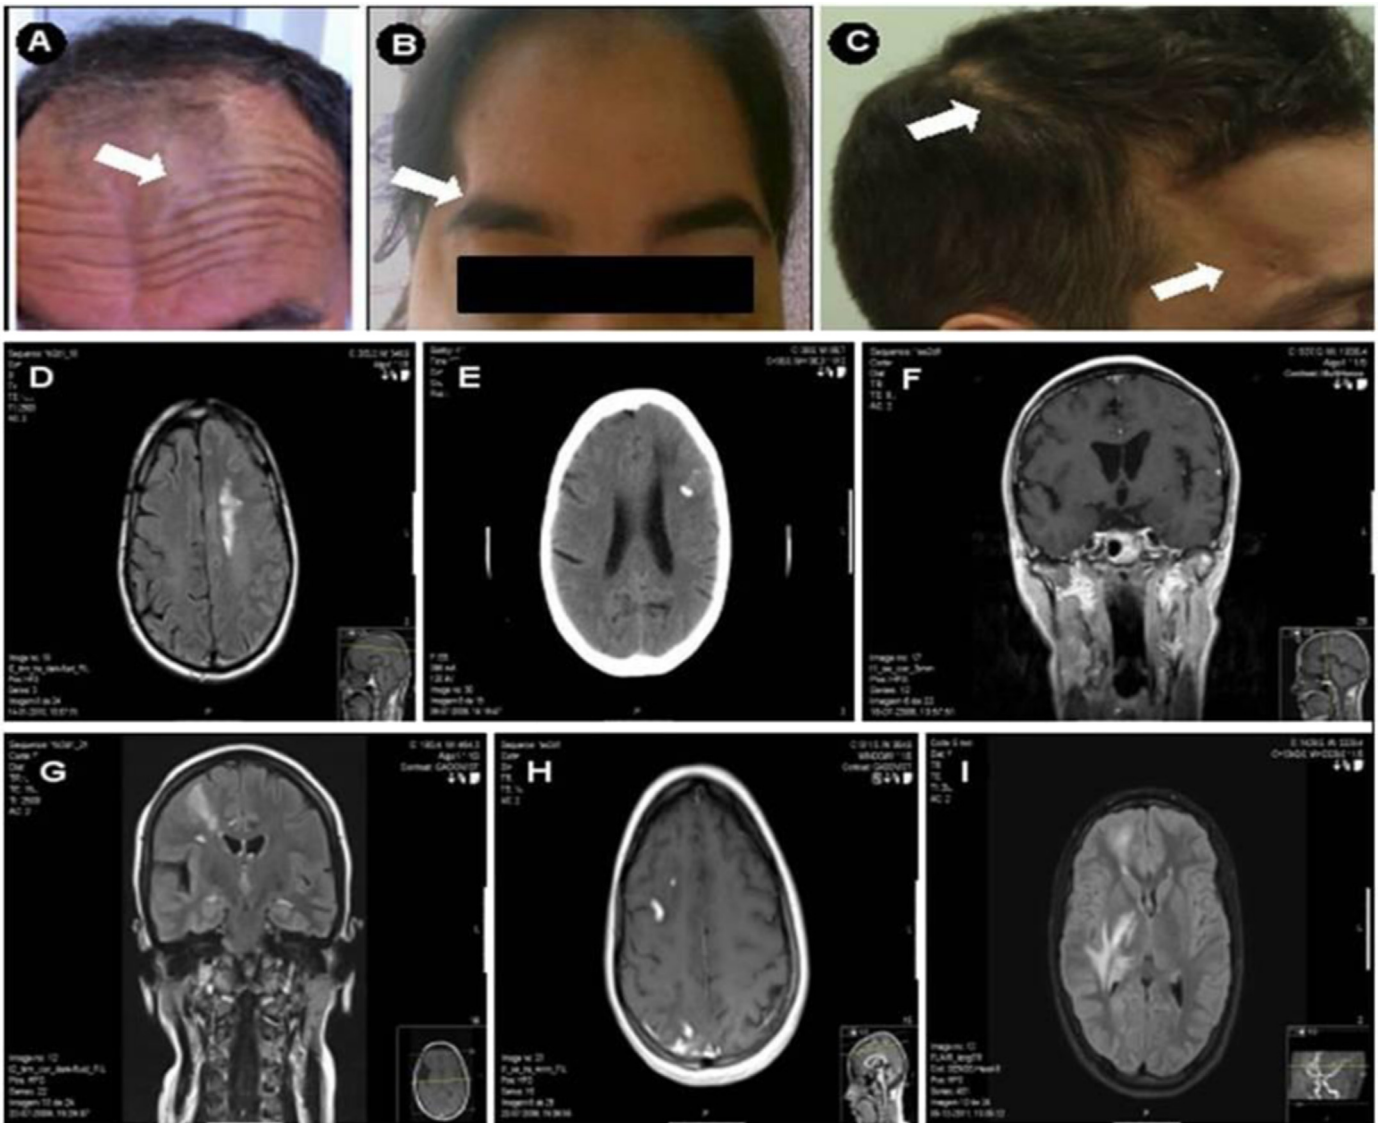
A–C: dermatological changes of scleroderma en coup de sabre, with focal skin atrophy and hyperpigmentation and underlying bone depression (arrows; case 1, 3 and 5 respectively). D: Case 1, FLAIR image shows left hemispheric sulcal effacement and a hyperintense white matter lesion. E–F: Case 2, CT-scan (E) reveals left frontal sulci effacement and a left subcortical hypodense lesion with calcifications, and contrast-enhanced T1(F) demonstrates left frontal skin and bone atrophy, with underlying dural enhancement and sulci effacement. G–H: Case 3, FLAIR (G) and contrast-enhanced T1 (H) depict hyperintense, contrast-enhancing white matter lesions underlying right frontal skin and bone atrophy. I: Case 4, FLAIR shows hyperintense right hemisphere lesions involving internal and external capsules, peritrigonal region, thalamus and subcortical temporal and frontal white matter.
